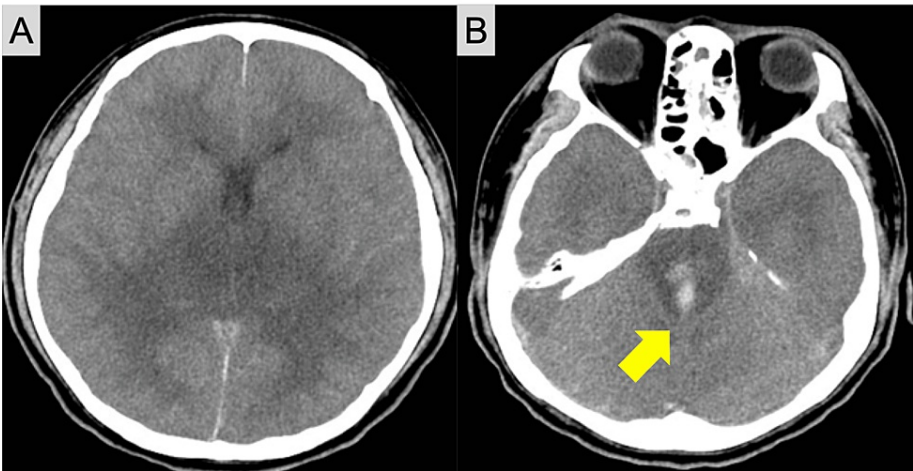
Head computed tomography (CT) scan after the resuscitation
